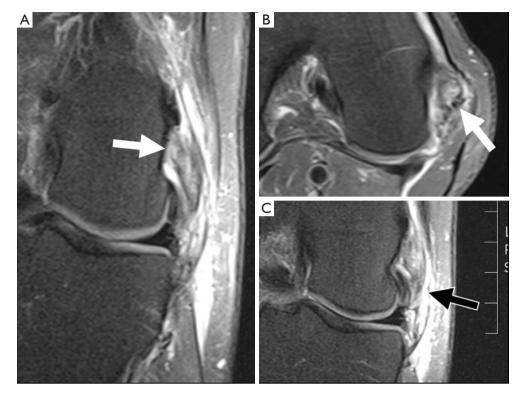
A 38-year-old man with a knee injury sustained while practicing Jiu-Jitsu. Magnetic resonance images in the coronal (A, B and C) plane with T2 weighted sequences with fat saturation. The images show high-grade injuries at the lateral collateral ligament origin (white arrows) and in the femoral portion of the anterolateral ligament (black arrow).
